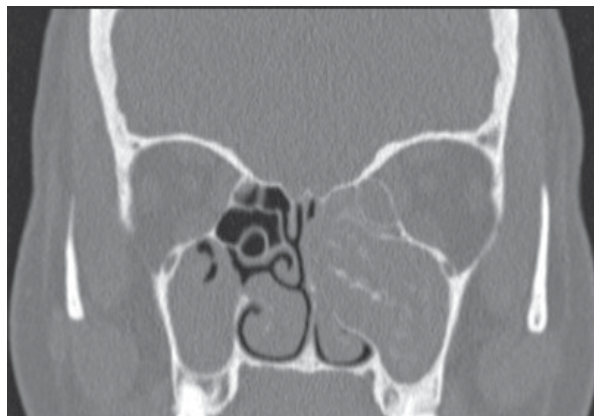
CT scan demonstrating typical features of AFS.
